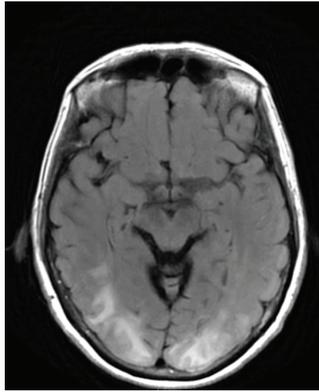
Axial T2 FLAIR image.
